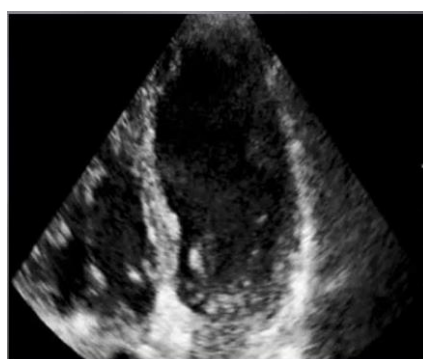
Transthoracic echocardiography, parasternal apical 4-chamber view, showing preservation of left ventricular systolic function and hypokinesis in the apical segment
